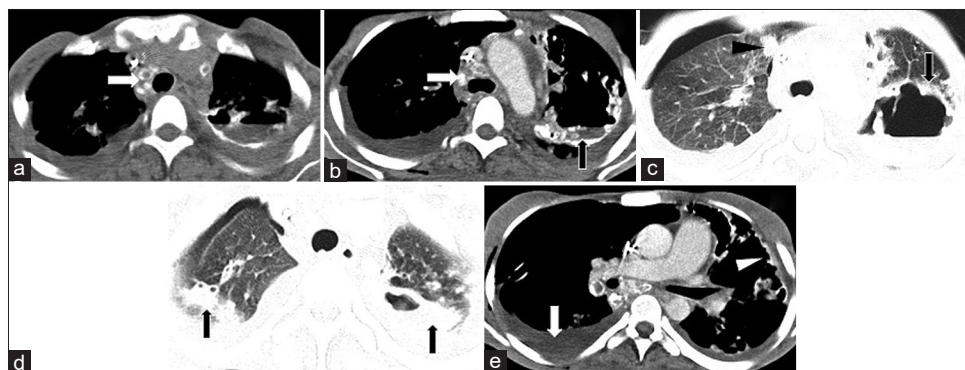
(a-e): 25-year-old female with active tuberculosis. (a-c) Multiple enlarged necrotic and calcified mediastinal lymph nodes (white arrows), thick walled cavity with dependent contents (black arrow) and solid nodule (arrowhead) (arrow). (d) Consolidation (arrows) and (e) showing pleural effusion (arrow) and pleural thickening (arrowhead) were also noted. Total CT-PECS score was 10 suggesting infectious aetiology
